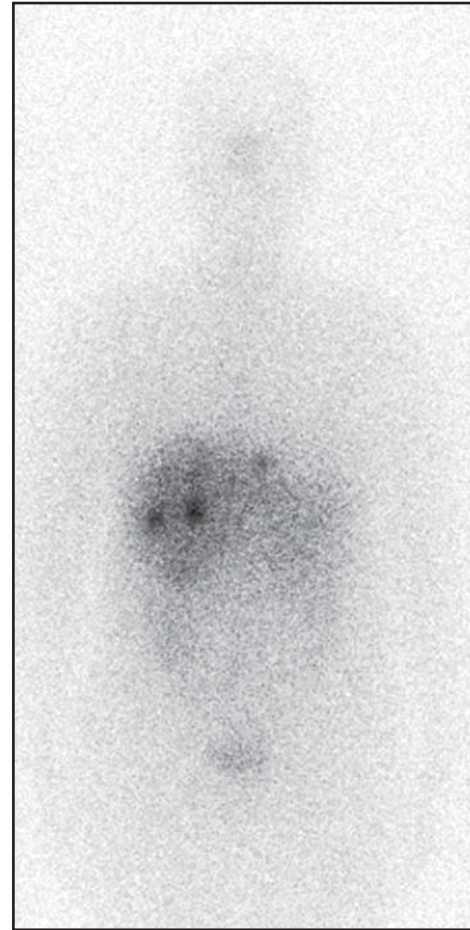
Posttherapeutic scintigraphy after administration of 100 mCi ^{90}Y -DOTA-TATE.
